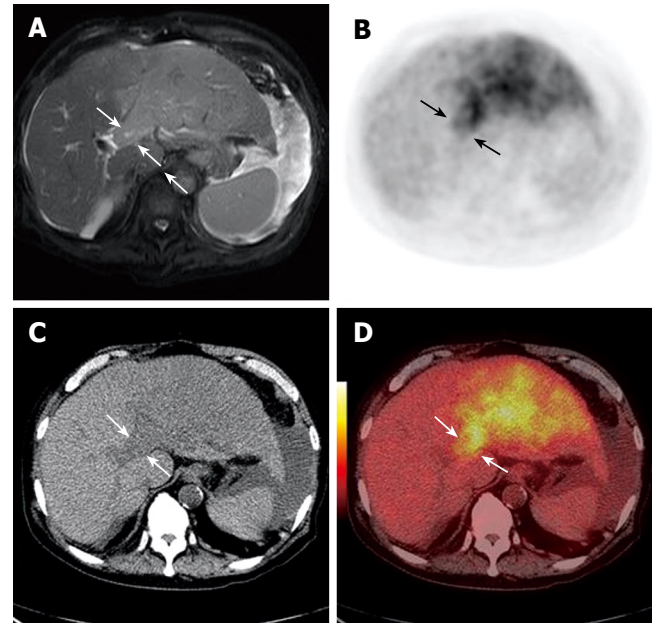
MRI scan showing a left lobe mass and portal vein thrombus in an 80-year-old man (white arrows, A). CT detected a low-density lesion in the left branch (white arrows, C). PET (black arrows, B) and PET/CT fused images (white arrows, D) reveal a highly metabolic thrombus in the left branch.
